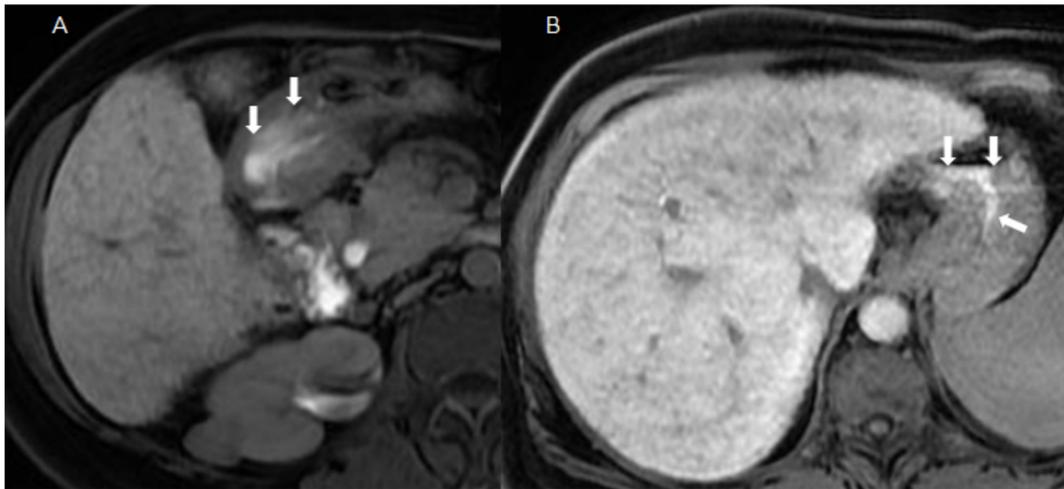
Axial gadoxetic-acid enhanced T1-weighted MR images of a 66-years-old female patient. Duodenogastric reflux into the gastric antrum in the hepatobiliary phase (A) and into the gastric corpus in the delayed phase (60 min after injection) (B). Upper endoscopy revealed bile reflux but no gastritis. Biopsy was not performed
